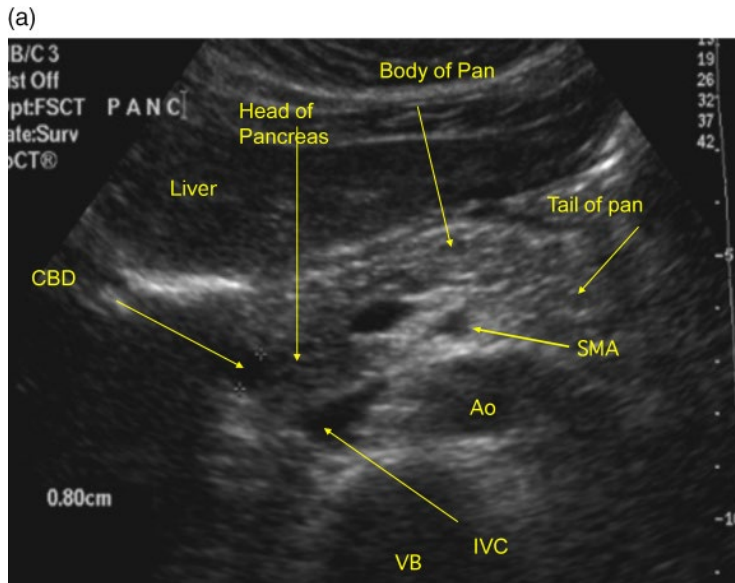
The anatomic structures seen in a transverse plane at the level of the pancreas in the upper abdomen. The vertebral body VB should be identified first, then, immediately anterior, the inferior vena cava (IVC) and aorta (Ao). The superior mesenteric artery (SMA) is usually directly anterior to the aorta. Anterior to that the splenic vein which runs posterior to the body and tail of the pancreas (arrowheads in b). The most anterior structure, forming a sonographic window is the liver (Li). CBD, common bile duct; GB, gallbladder; LRV, left renal vein.
